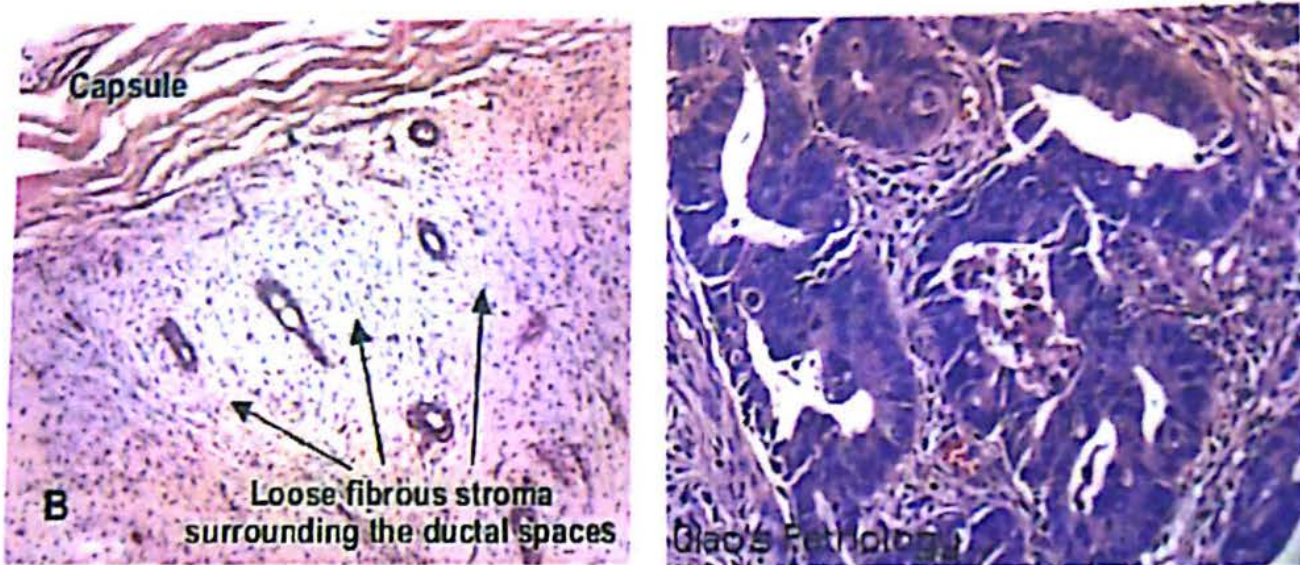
Left: Fibroadenoma showing regular glands separated by stroma, and surrounded by CT capsule. Right: Adenocarcinoma showing irregular glands lined by multiple layers of pleomorphic cells with hyperchromatic nuclei.
